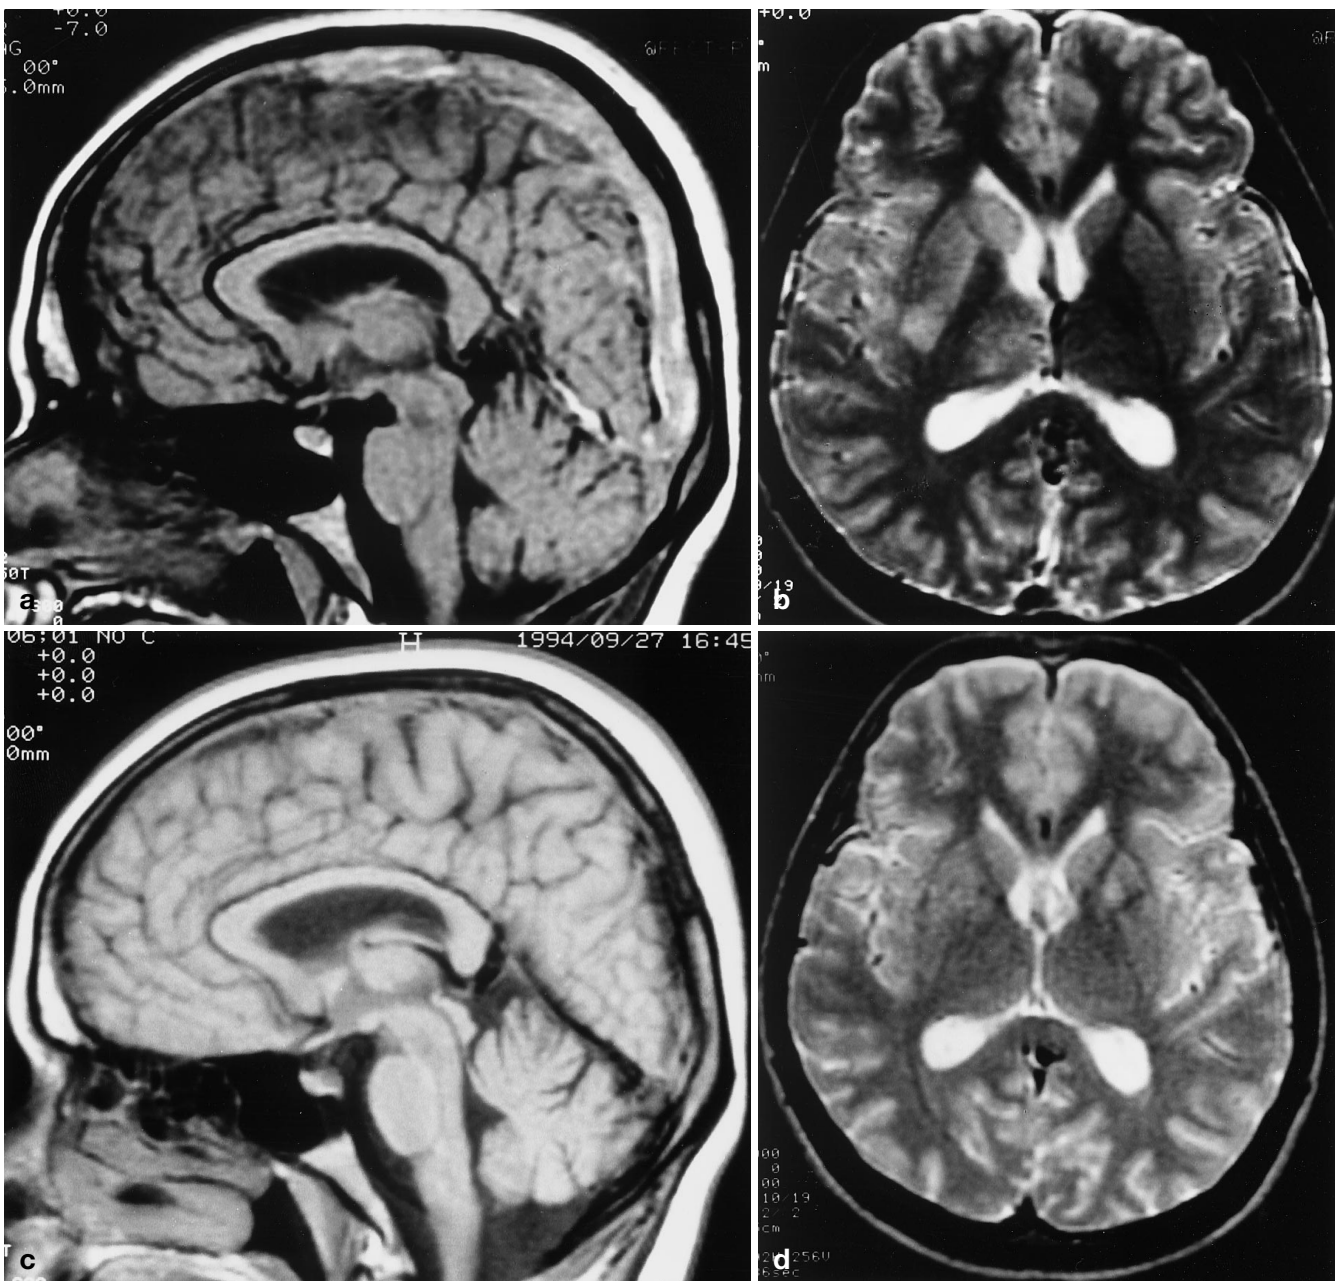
Case 4. a Sagittal T1-weighted image shows high signal in the SSS, straight sinus, and isointense internal cerebral vein and vein of Galen. b Axial T2-weighted image shows high signal in the right thalamus and caudate and lentiform nuclei. c Sagittal T1-weighted image 5 months later reveals flow void in the right internal cerebral vein, vein of Galen and straight sinus. The torcular herophili and SSS show irregular areas of isointense signal. d Axial T2-weighted image 8 months after onset shows disappearance of parenchymal abnormalities and normal appearance of the internal cerebral veins
